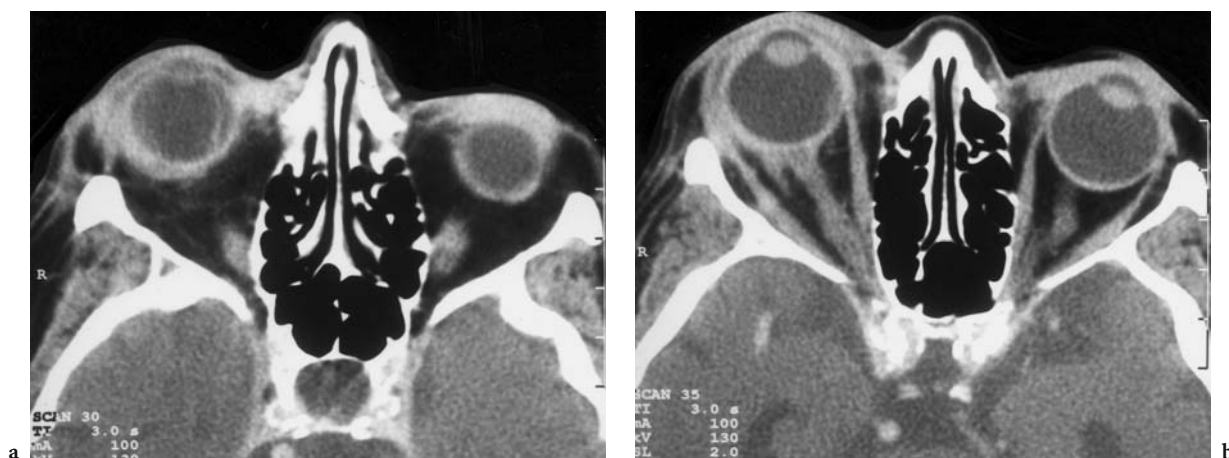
An 83-year-old woman with chronic articular rheumatism, presenting with subacute (onset 4 weeks prior to presentation) painful swelling and protrusion of the right eye. Diagnosis: posterior scleritis and retinal detachment. Axial contrast-enhanced CT: a Despite swelling of the posterior part of the sclera, a crescent-shaped bilateral retinal detachment is apparent in the inferior part of the right globe. b Paraoptic retrobulbar inflammation as well as some medial retinal detachment are seen at the level of the optic nerve in the protruded right globe
